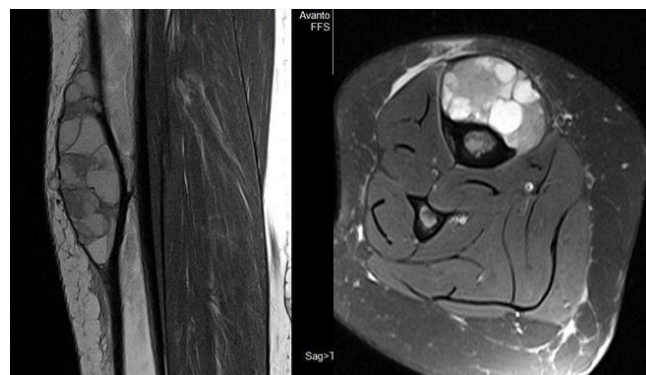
T2 sagittal and T2 FS axial MRI showing multiseptated heterogenous signal intensity lesion arising from cortex of tibia.
